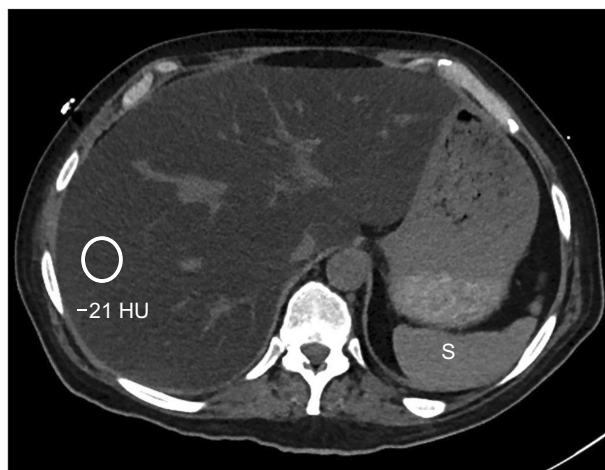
Severe hepatic steatosis on computed tomography (CT). Axial non-contrast enhanced CT shows diffuse hypoattenuation of the liver parenchyma. The mean Hounsfield unit (HU) is -21 HU, which is consistent with severe steatosis. Note the spleen (S) is hyperdense compared to the liver
